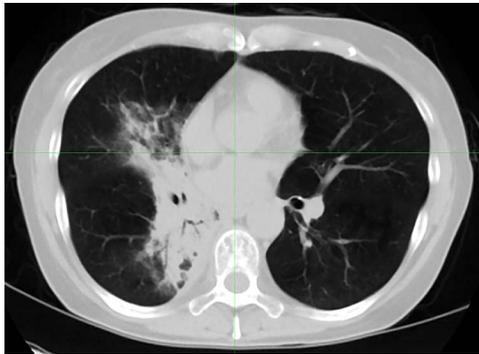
Chest computed tomography image of same patient. Consolidation shadow appeared in irradiated field.
